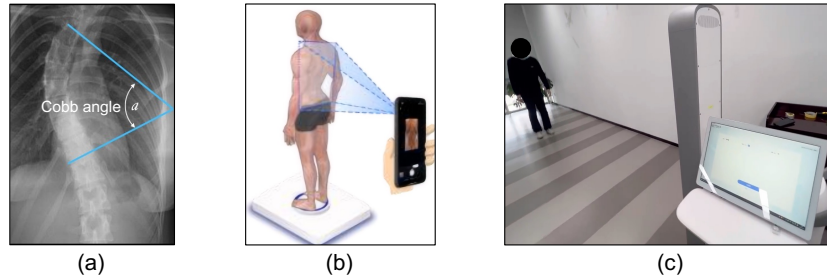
Comparative overview of scoliosis diagnosis methods: (a) Traditional X-ray examination, the clinical gold standard [18]; (b) Non-invasive analysis of bare back photos [24]; (c) Our proposed gait analysis approach, which enables efficient, large-scale early adolescent screening to identify cases needing further radiographic investigation, highlighting its non-invasiveness and privacy-preserving nature.
